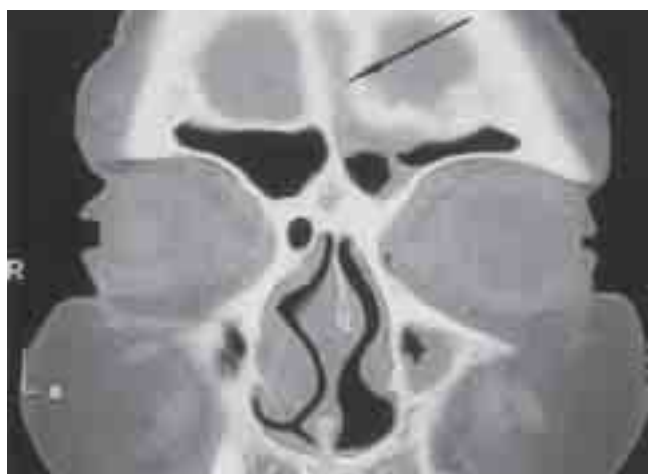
Patient C: Pre-operative coronal CT scan view of persisting concretion in the left frontal sinus (black arrow).
